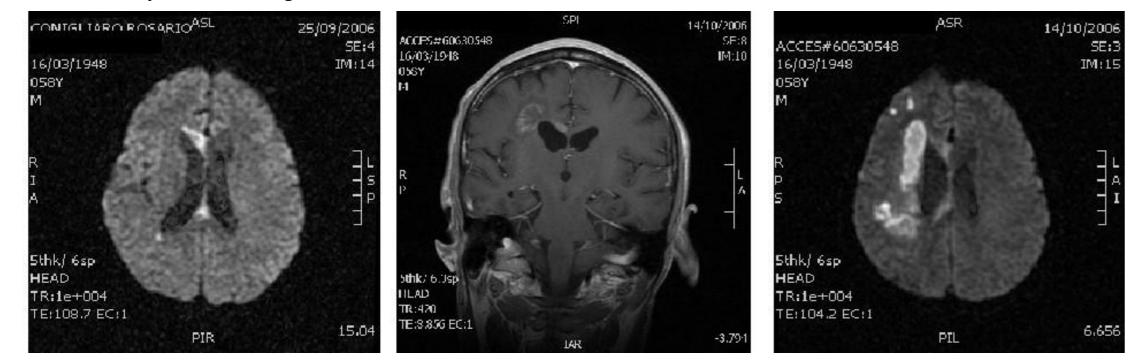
Patient R. C. MRI on DWI and T2-weighted; at 1 month the area of diffusion restriction on DWI moved laterally and the corpus callosum lesion became inactive.
